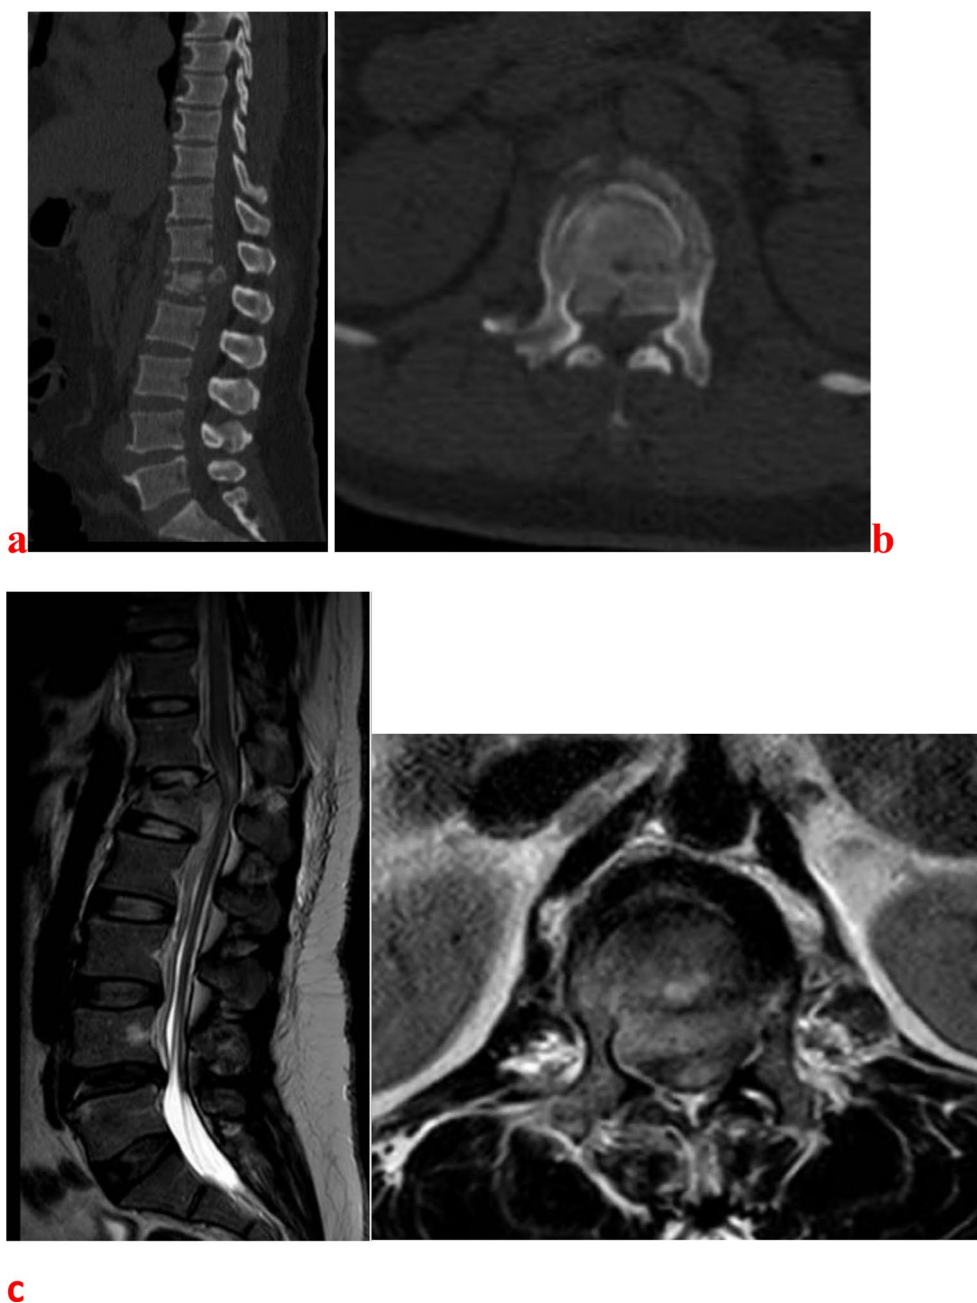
Preoperative imaging of a patient with a traumatic L1 burst fracture and retropulsion causing spinal canal stenosis: (a) sagittal CT, (b) axial CT, (c) sagittal MRI, (d) axial MRI
